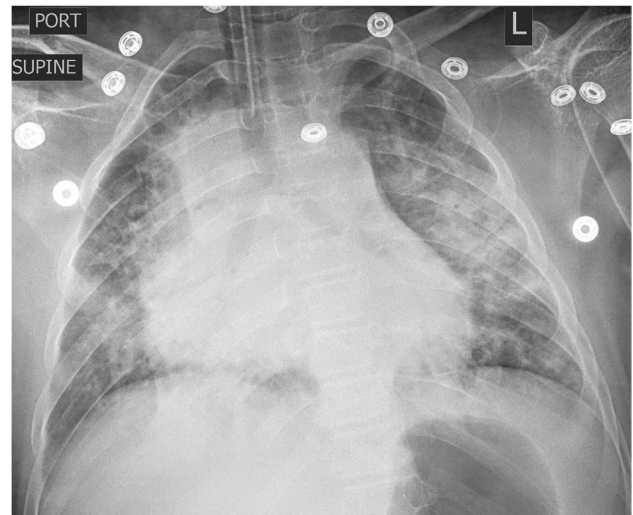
Dense consolidation on radiography in acute coronavirus disease 2019 (COVID-19) pneumonia in a 14-year-old boy. The boy had a history of seizure disorder. He presented with fever and respiratory distress. Anteroposterior chest radiograph demonstrates diffuse ground-glass opacification of the lungs, with bilateral perihilar and retrocardiac dense consolidation
